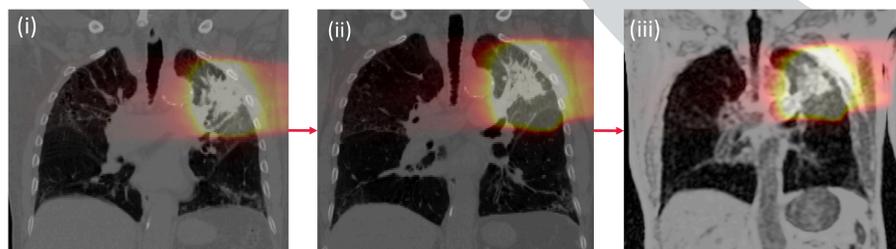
(i-vi) – Images of the registrations for a representative patient. (i) depicts the free breathing CT fused with the RT dose. This was then sequentially registered to the inspiratory CT image (ii) and same breath ¹H MR image (iii). The RT dose shown in a 'hot' overlay in images (ii and iii) is the transformed dose according to the registrations output transform fields at each step. (iv) is the DCE lung perfusion MR image and is registered to the same breath ¹H MR images where it is shown as a 'jet' overlay in (v). (vi) shows the patient's ¹H MRI with the HP ³He MRI as a 'jet' overlay.
